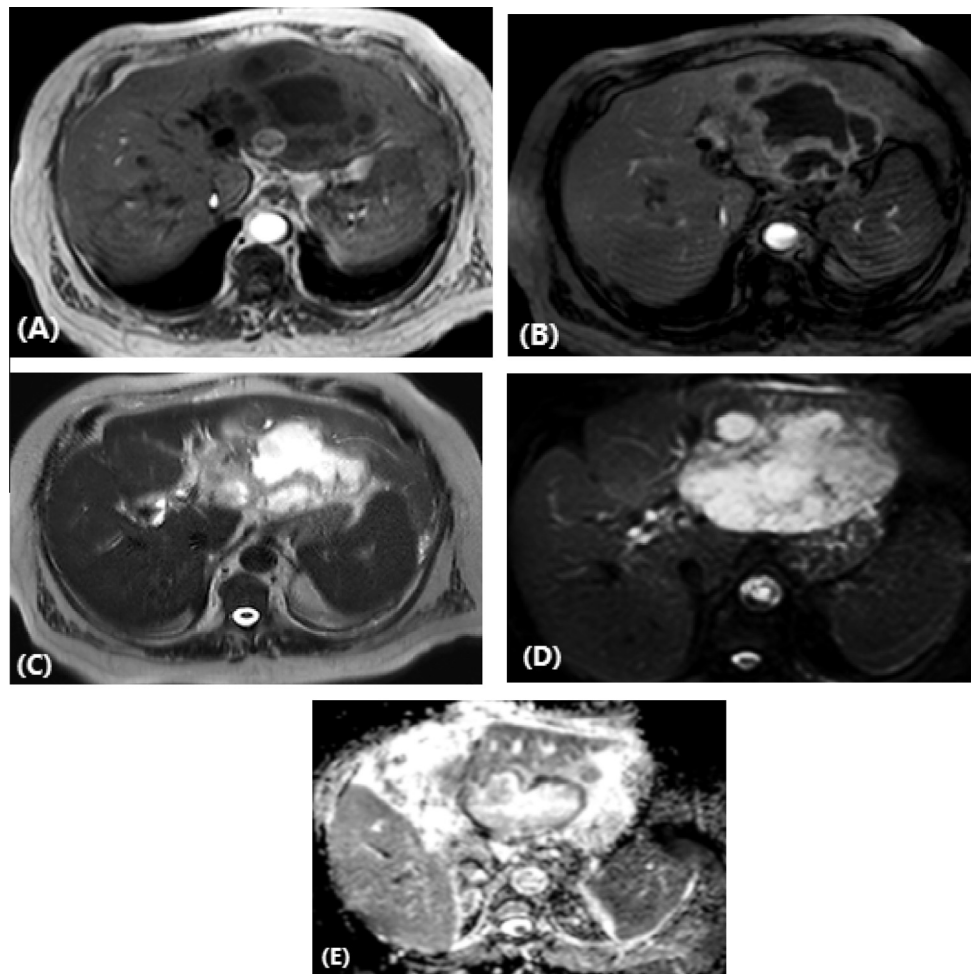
Liver abscess in a 72 year-old male patient. (A) Axial T1-weighted image shows a multiloculated hypointense cystic lesion in the left lobe. (B) Axial T1-weighted image following intravenous contrast injection at the same level of (A) and shows intense marginal enhancement. (C) Axial T2-weighted image discloses a hyperintense abscess cavity. (D) Axial single-shot echo-planar DW image ($b = 600$), the abscess persists with high signal intensity with ADC value [$1.7 \times 10^{-3} \text{mm}^2/\text{s}$] (E).
